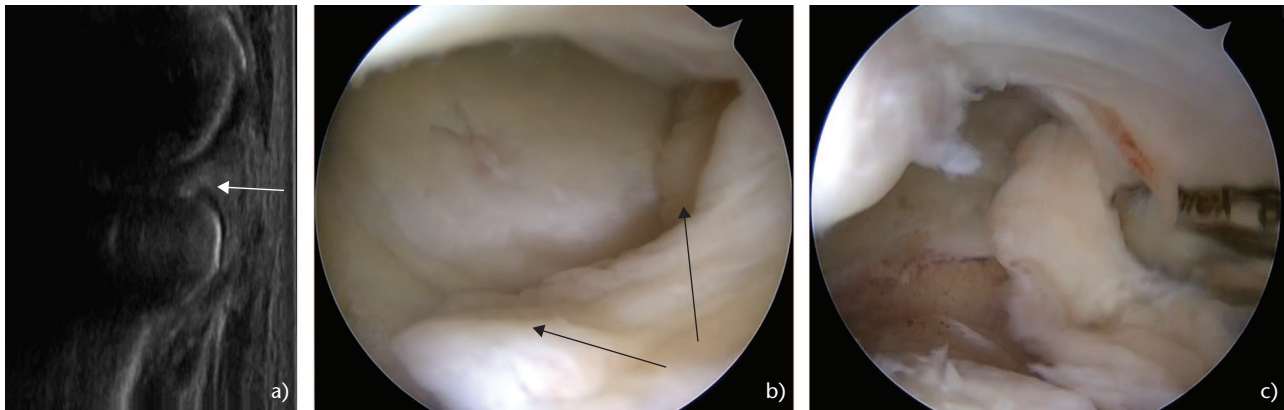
The posterior plica of a radio-capitellar joint. Magnetic resonance imaging (a, b), white arrows pointing to the plica; arthroscopic picture from posterolateral of the posterior plica, (c) black arrow pointing to the plica.
